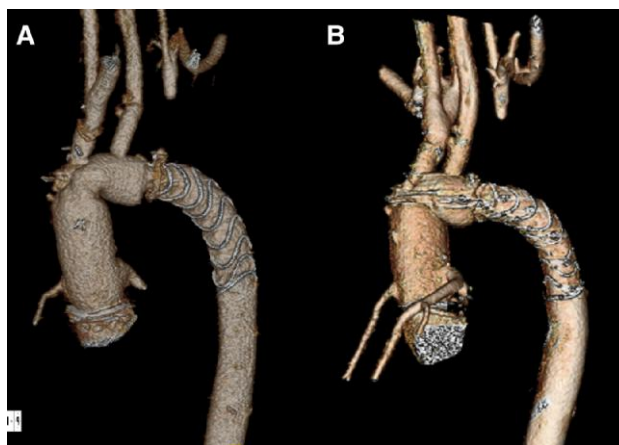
(A) Cardiac CTA at 2 months follow-up with no residual stenosis. (B) Cardiac CTA at 1 year follow-up with no recurrent stenosis (resolution: 300 dpi).
